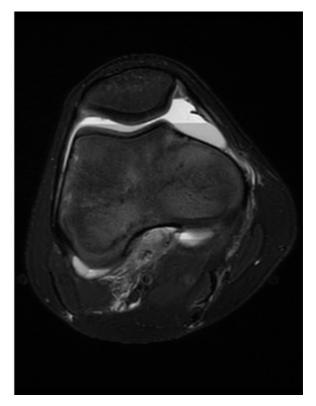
Axial T2-weighted magnetic resonance image demonstrates lipohemarthrosis with 2 fluid-level demarcations and heterogeneous signal intensity within the bone marrow of the distal femur (fast-recovery, fast spin echo, fat-suppressed image).
